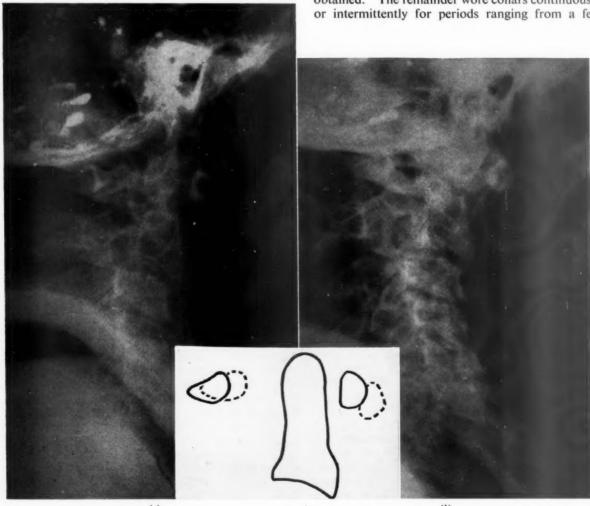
Case 27; radiographs in the second Minerva plaster.
